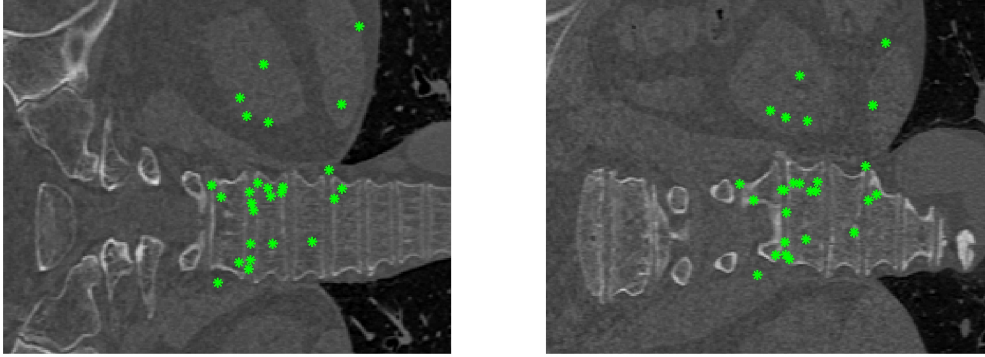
Two CT slices of a target (*left*) and atlas (*right*) with corresponding features after RANSAC for Lumbar Vertebra 1.
